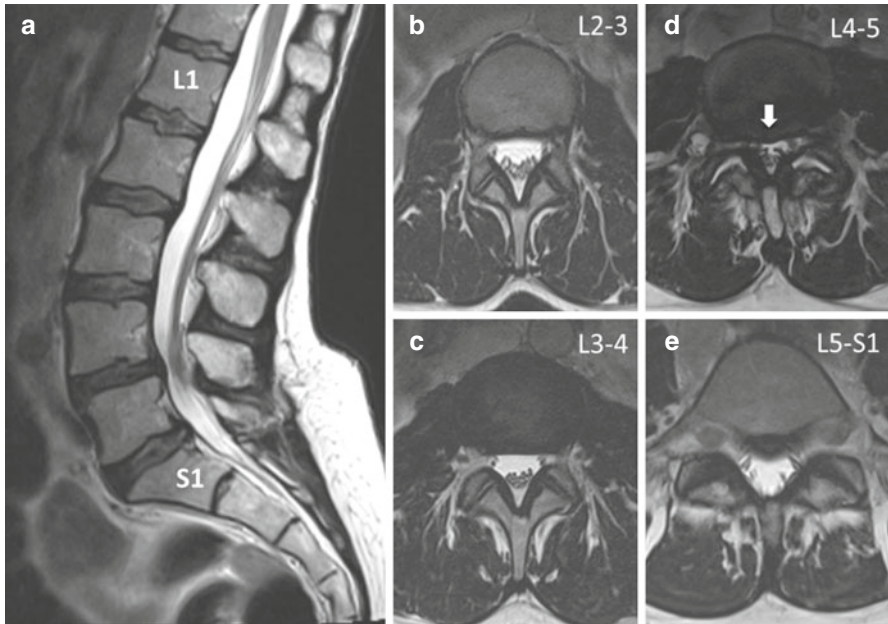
(a) Midsagittal MRI demonstrating the L1–S1 vertebrae in a 47-year-old female. (b–d) Axial views of the facet joint from L2–L3 to L5–S1 vertebrae. Each vertebra connects to an adjacent vertebra with two facet joints (b–e) and intervertebral disc to form the three-joint complex that makes up the spine functional unit. As can be seen, the orientation of the facet joints progressively changes from a more horizontal orientation at L5–S1 to a more oblique or vertical orientation at L2–L3. This enables complex kinematics of the lumbar spine. Also demonstrated in (d) is the evidence of facet joint OA, with hypertrophy of the bony articulations and the ligament that is resulting in stenosis of the spinal canal (*white arrow*) compared to other levels where the facets are essentially normal in appearance. In addition, there is minimal disc degeneration in this particular patient
